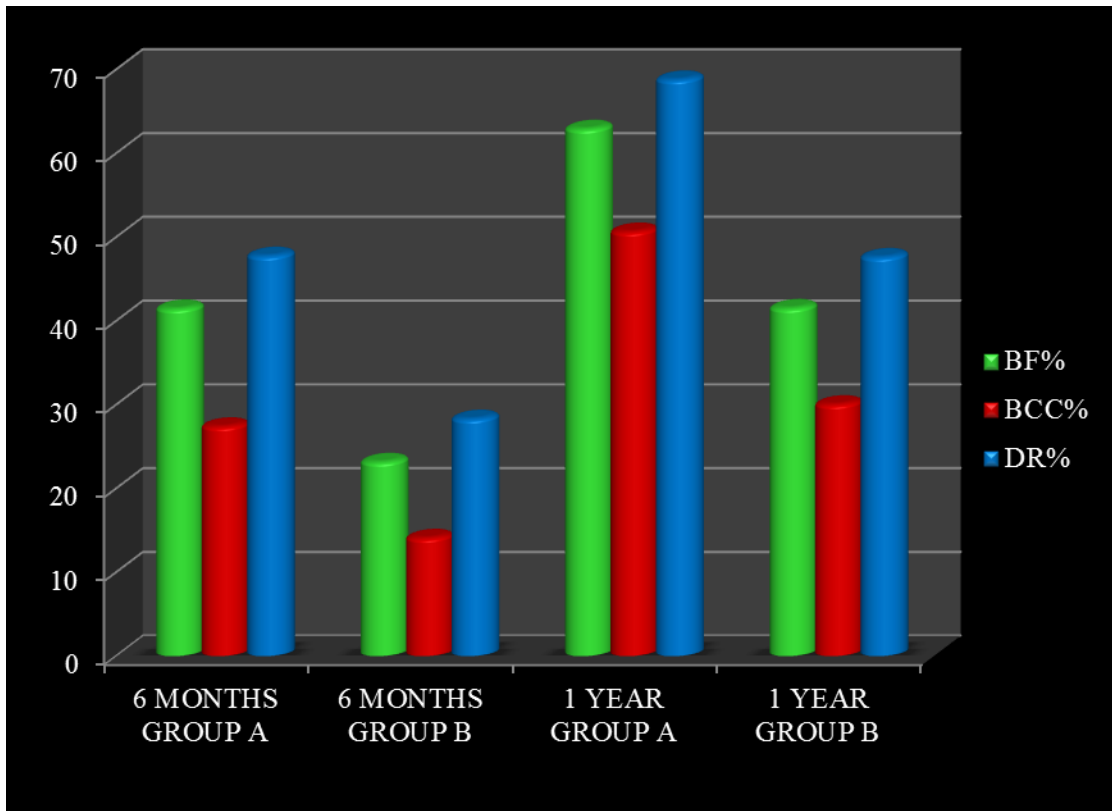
Comparison of Radiographic parameters
